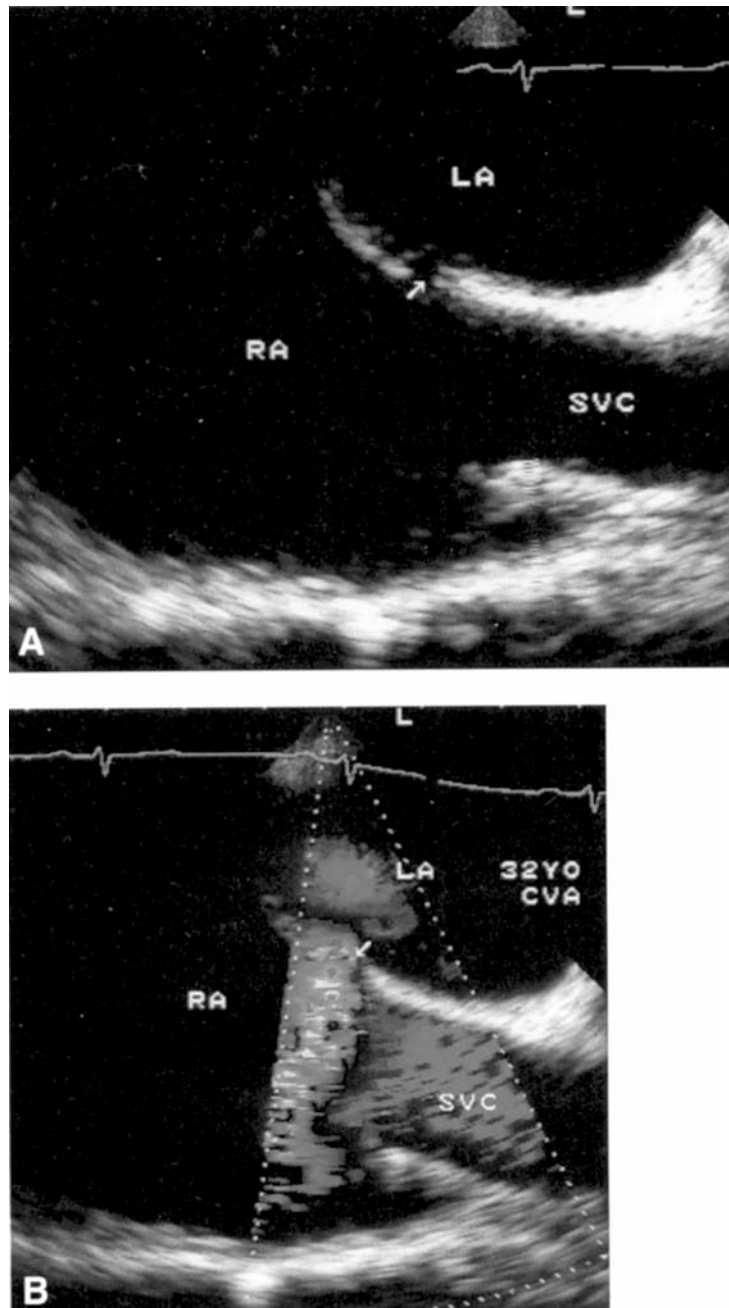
Longitudinal transesophageal echocardiography (TEE) imaging in the mid-upper esophagus. A 32-year-old male presented with an embolic stroke. He was found to have occult thrombi in both calf veins. Transthoracic echocardiography with peripheral saline contrast during normal respiration and Valsalva were negative for a right-to-left shunt. (A) TEE revealed a small restrictive secundum atrial septal defect (ASD) (arrow). Note how this appearance is different from that of a patent foramen ovale. (B) Color Doppler demonstrates a left-to-right shunt with a color mosaic pattern from the shunt in the right atrium (RA). The ASD was subsequently surgically repaired. LA = left atrium; SVC = superior vena cava. (From Kerut, E. K. et al. (2001). *J. Am. College Cardiol.*, 38(3), 618.)
